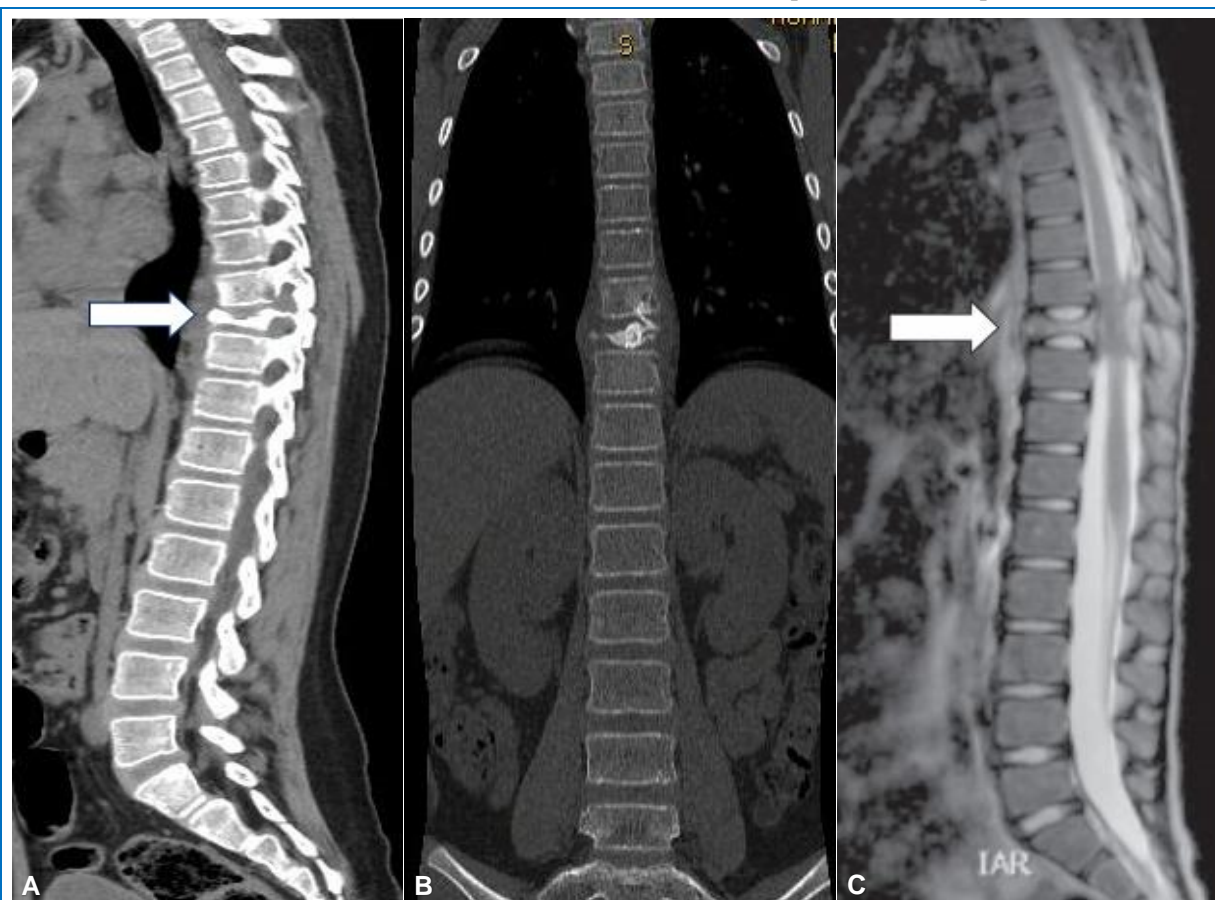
(A) Tomography (TEM) of the dorsolumbosacral spine (DLS) in sagittal section showing a decrease in the height of the D9 vertebral body. (B) TEM DLS column in coronal section showing asymmetric decrease in the height of the D9 vertebral body with extension to paravertebral soft tissues. (C) MRI in sagittal section and T2 sequence showing destruction of the D9 vertebral body, with a mass that invades 50% of the medullary canal and contacts the spinal cord in its anterior and posterior portion.
